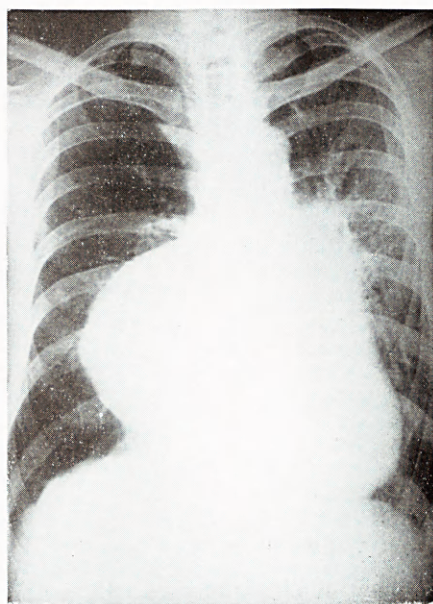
X-ray film showing apparent aneurysmal dilatation of the left auricle, enlargement of the left ventricle and pulmonary conus, the appearances suggesting combined mitral and aortic valvular lesions.
